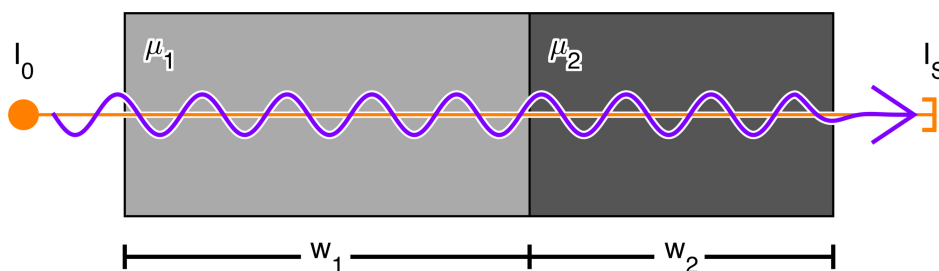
Modeling X-ray attenuation: An X-ray source (orange dot, left) emits monochromatic X-radiation with initial intensity I_0 . The detector (orange ‘bucket’, right) reads a radiation intensity of $I_S = I_0 \cdot \exp(-\int_L \mu(\mathbf{x}) \, d\mathbf{x})$, following the Beer-Lambert law. In this case, assuming two discrete blocks with lengths w_1 , w_2 and homogeneous attenuation coefficients μ_1 , μ_2 in vacuum, the expected sensor reading is $I_S = I_0 \cdot \exp(-\mu_1 \cdot w_1 - \mu_2 \cdot w_2)$.
